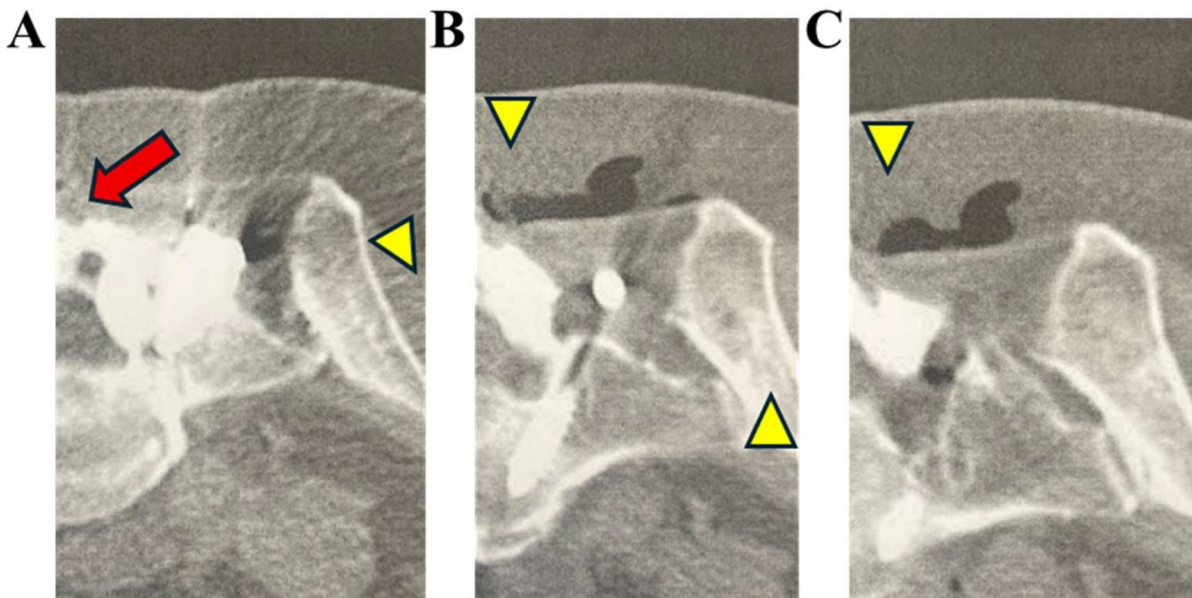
Patient with chronic low back pain following spinal stabilization, complicated by left-sided sciatica. Electromyographic examination showed chronic neurogenic impairment in the S1 left distribution territory. (A) Low-dose parenchymal algorithm computed tomography (CT) scan confirming needle placement (arrow). (B-C) CT control scans documenting the distribution of the gas mixture (arrowheads).
